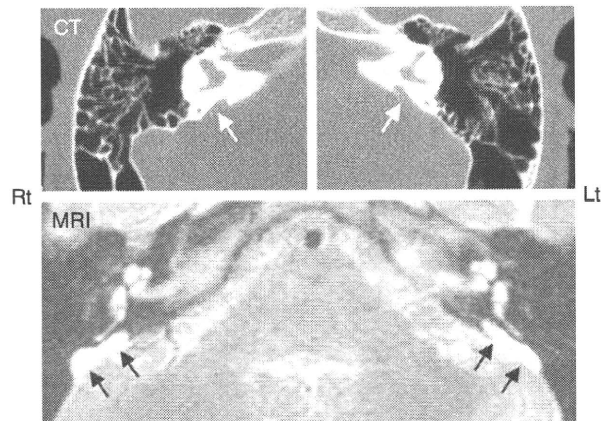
High-resolution computed tomography (CT) and magnetic resonance imaging (MRI) of the temporal bones in the proband. Bilateral enlargement of the vestibular aqueduct and endolymphatic sac (arrows) is evident.
